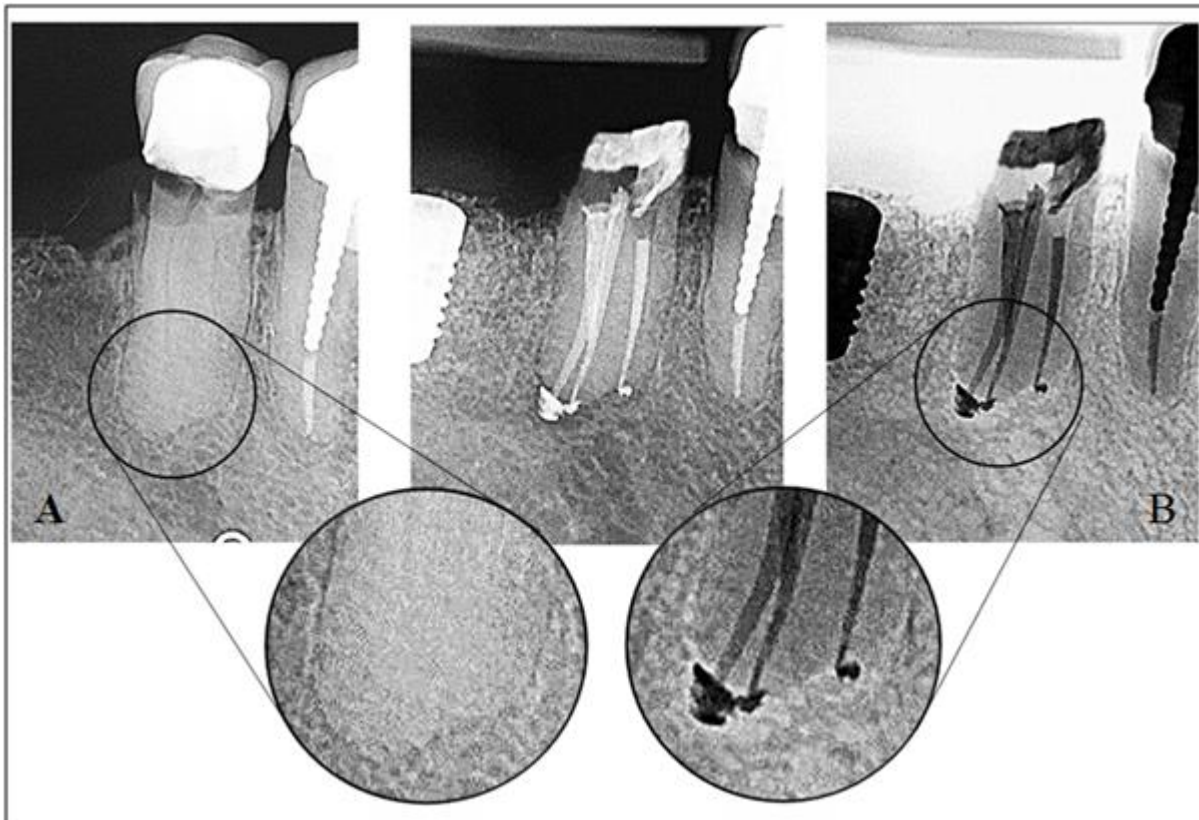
A/ Preoperative radiograph on tooth #45; B/ Control radiograph after definitive obturation with single-cone technique and AH Plus sealer. The three separate apical foramens (apical portals of exit) are clear visibly at zoom image
